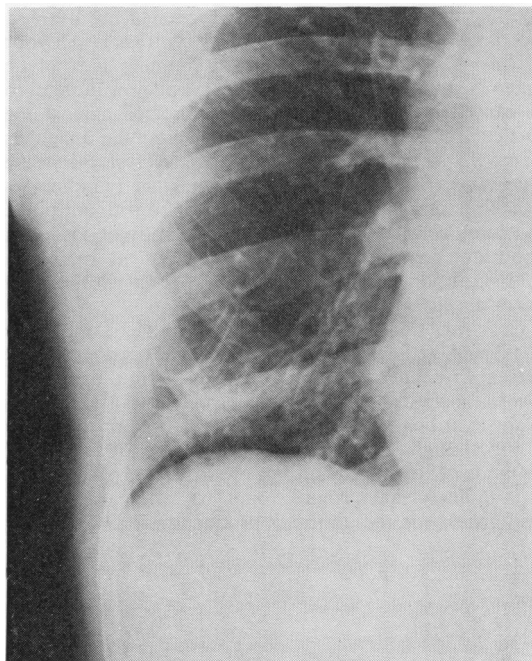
Figure Chest radiograph showing basal shadowing and thin-walled bullae.
